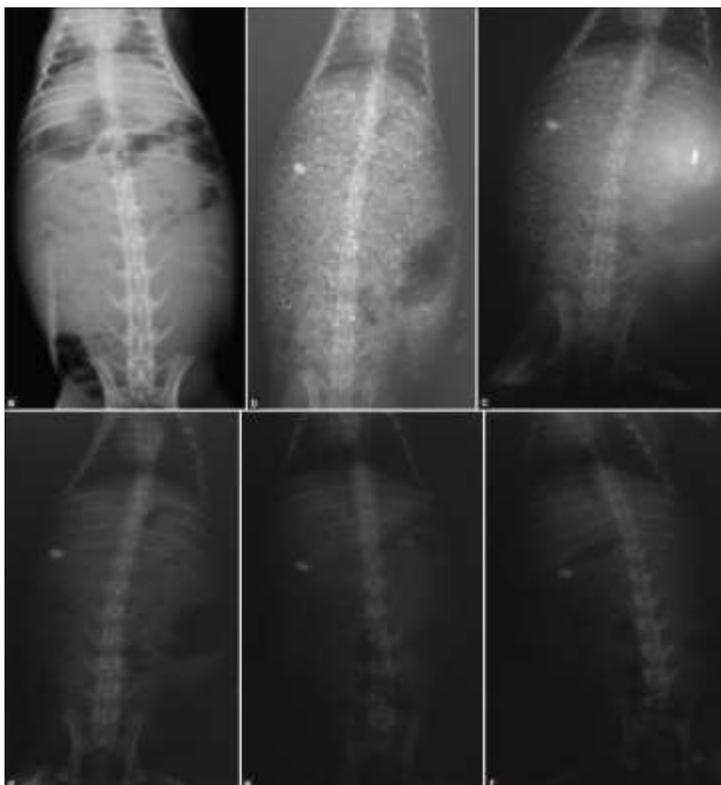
X-ray photographs at different time intervals of gastroretentive floating tablets (a) X-ray at 0 h. (b) X-ray after 2 h. (c) X-ray after 4 h. (d) X-ray after 6 h. (e) X-ray after 8 h. (f) X-ray after 10 h
